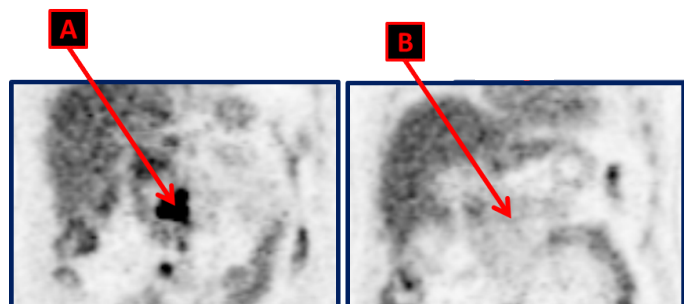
FDG PET CT scan done at the moment of the disease recurrence, showing hypermetabolic lymphadenopathies in the retroperitoneal space (A). They disappeared with complete metabolic response (B) on the FDG PET CT scan repeated after 4 cycles of Cisplatin and Etoposide.
